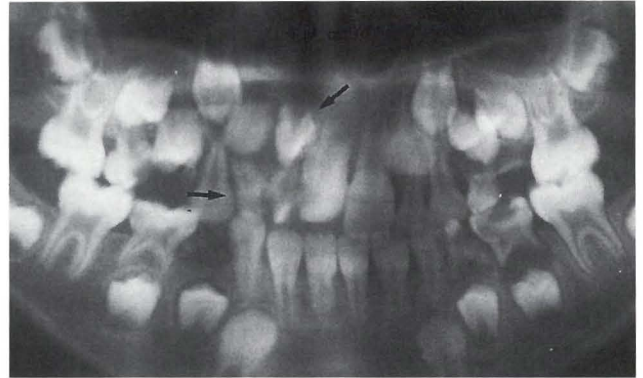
Panoramic radiograph of a patient with unilateral cleft (on the right side) showing a supernumerary maxillary lateral incisor both in the primary and permanent dentitions.
